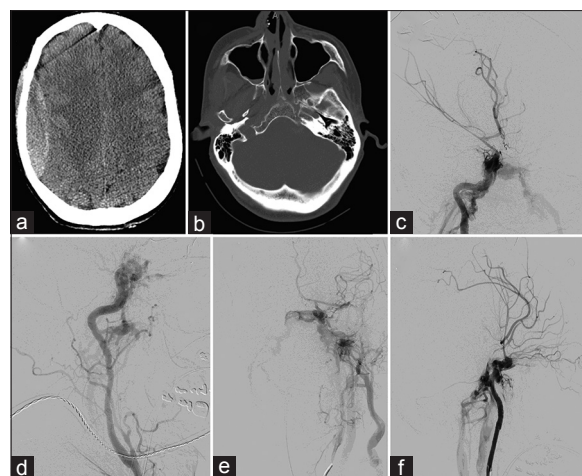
Bilateral blunt cerebrovascular injury (BCVI) with associated high-flow carotidocavernous fistulas (CCFs) is shown. (a) Non-contrast axial CT demonstrates a 1.8-cm right EDH with 6 mm of right-to-left shift. (b) Axial bone window CT shows no acute skull-base fracture or injury in the area of the carotid canal. (c) Townes and (d) lateral digital subtraction angiographic (DSA) images during right internal carotid artery (ICA) injection undertaken after the patient continued to have uncontrolled bleeding intraoperatively show a direct CCF with drainage through the bilateral inferior petrosal sinuses. Flow through the anterior cerebral (ACA) and middle cerebral (MCA) arteries was significantly slow, with displacement of the MCA branches due to mass effect. (e) Townes and (f) lateral DSA images of a left ICA injection show a direct CCF with outflow through the inferior petrosal sinuses, as well as egress through the left external jugular system. Flow through the ACA and MCA was diminished
